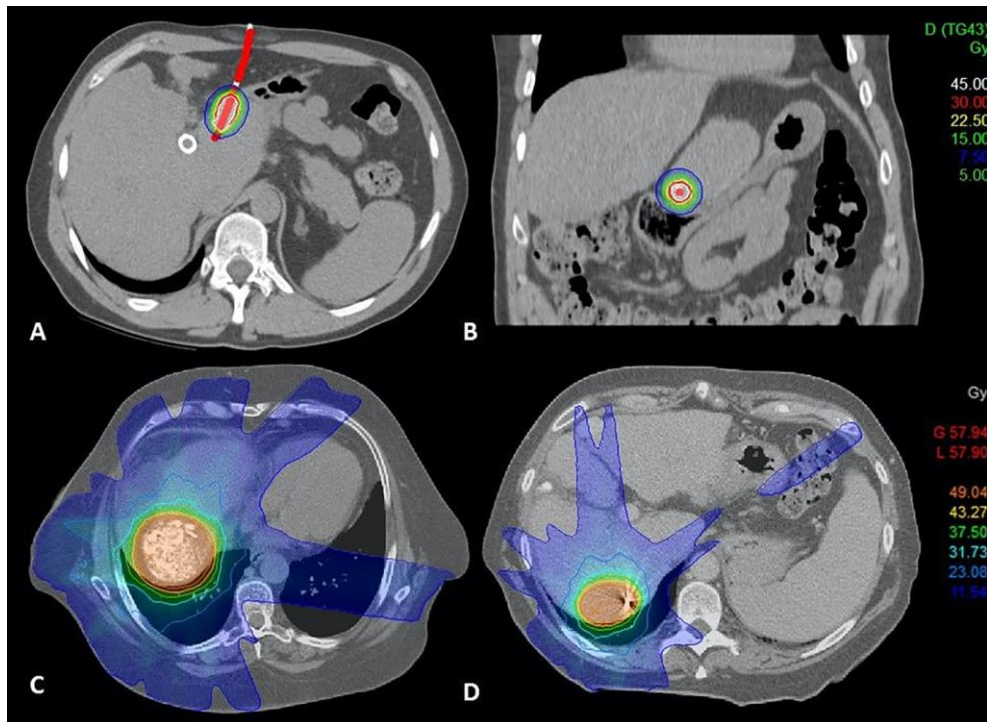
(A) and (B) shows BT dose distribution in coronal and sagittal views. (C) and (D) shows SBRT dose distribution in different CT slices (Walter et al., 2021).
